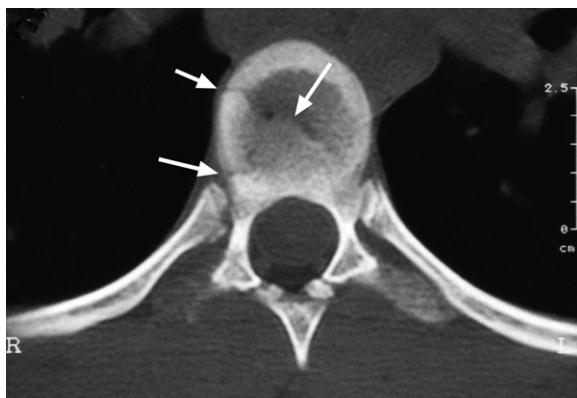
CT axial image through the T7 vertebra. Note the incomplete body union at the fracture sites (white arrows). R = right side of patient.
